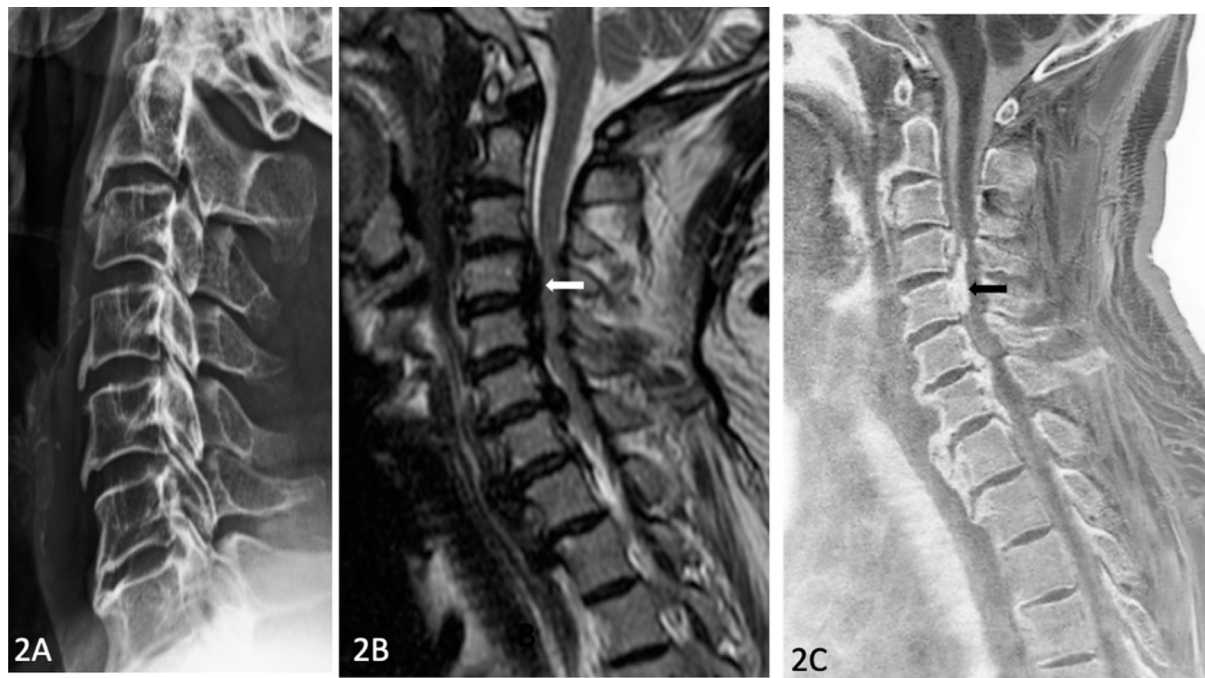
72-year-old male with cervical OPLL and compressive myelopathy. (A) Lateral cervical radiograph – no evidence of ossified posterior longitudinal ligament. (B) Sagittal T2-weighted MRI showing OPLL and multiple osteophytes (arrow). (C) Sagittal BTFE showing the OPLL with sharper delineation of extent and thickness (arrow).
